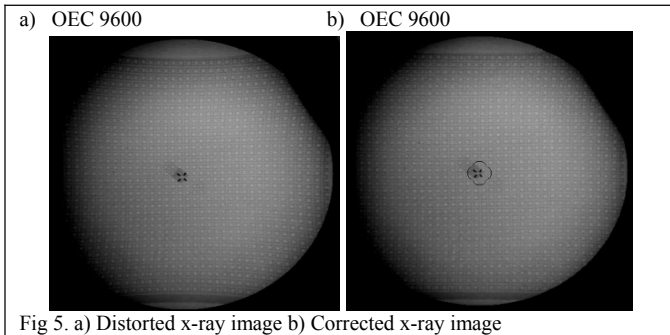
a) Distorted x-ray image b) Corrected x-ray image
